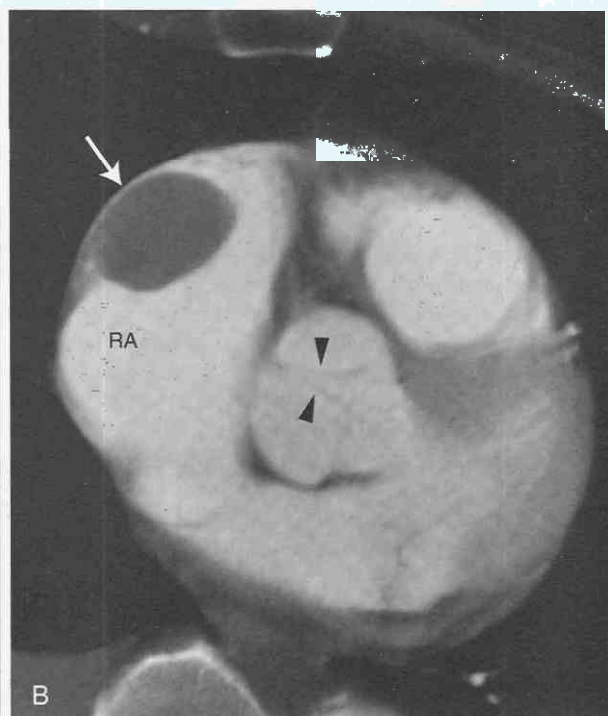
Clot in right atrial appendage. Contrast-enhanced axial CT images show (A) a large filling defect in the right atrial appendage (*arrow*) and (B) extension into the right atrium. The right atrium is enlarged. Thrombus was also found in the pulmonary arterial tree (not shown). There is calcification of the left anterior descending artery (*curved arrow*). RA, right atrium. The *arrowheads* point to cusps of aortic valve.
